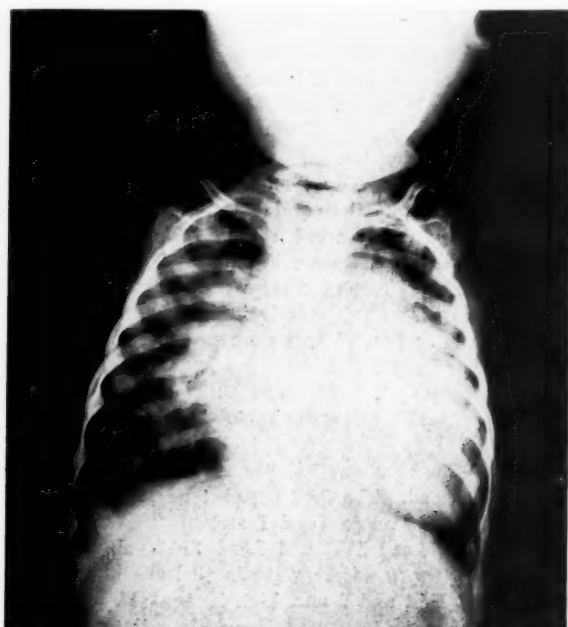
Roentgenogram showing marked enlargement of the cardiac outline and marked pulmonary congestion.
